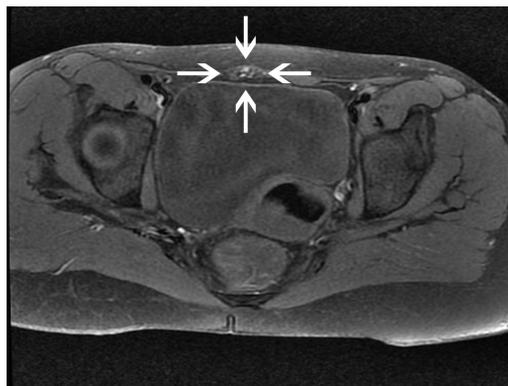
MRI- Axial T1- enhanced T1-weighted fat-suppressed showing a mass (white arrows) within the anterior abdominal wall abutting the right rectus abdominis muscle with foci of hyper-intensity suggesting hemorrhage.
